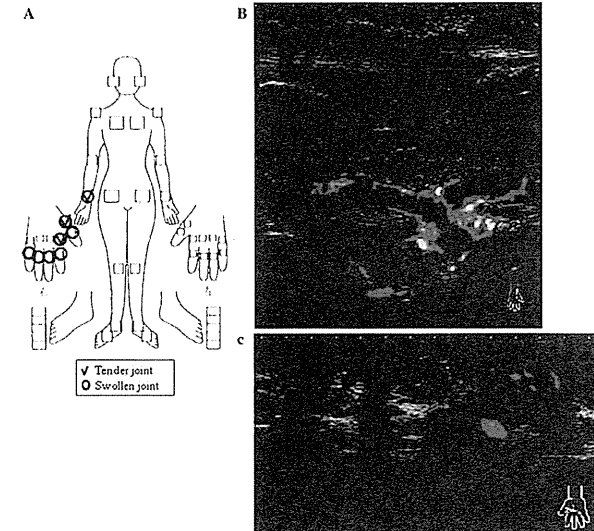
The findings of physical examination and musculoskeletal ultrasonography (MSKUS) at initial visit. a She had 3 tender joints and 8 swollen joints of right wrist and fingers on physical examination. b First compartment (abductor pollicis longus and extensor pollicis tendons) of the extensor tendons on the dorsal aspect of the wrist. Images obtained in longitudinal scan using grayscale (upper) and power Doppler mode (lower). Images show typical
